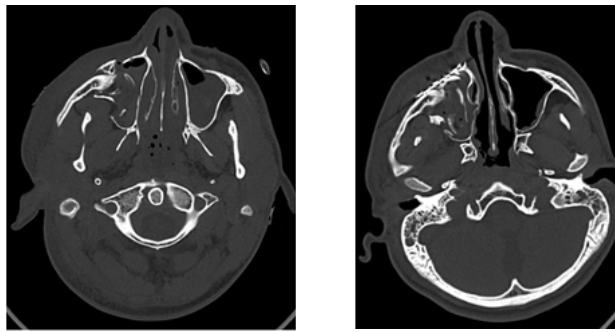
Pre op and Post op CT Axial view showing reconstructed zygomatic prominence
